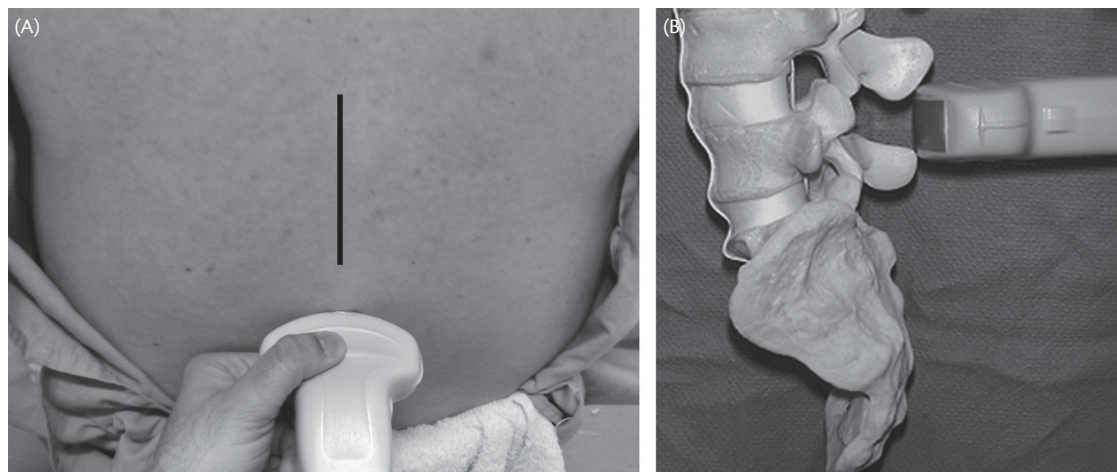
(A) Ultrasound probe orientation in transverse median plane (TM PLANE) (B) Ultrasound probe orientation in transverse median plane (TM PLANE) — Lateral view in relation to Spine.
